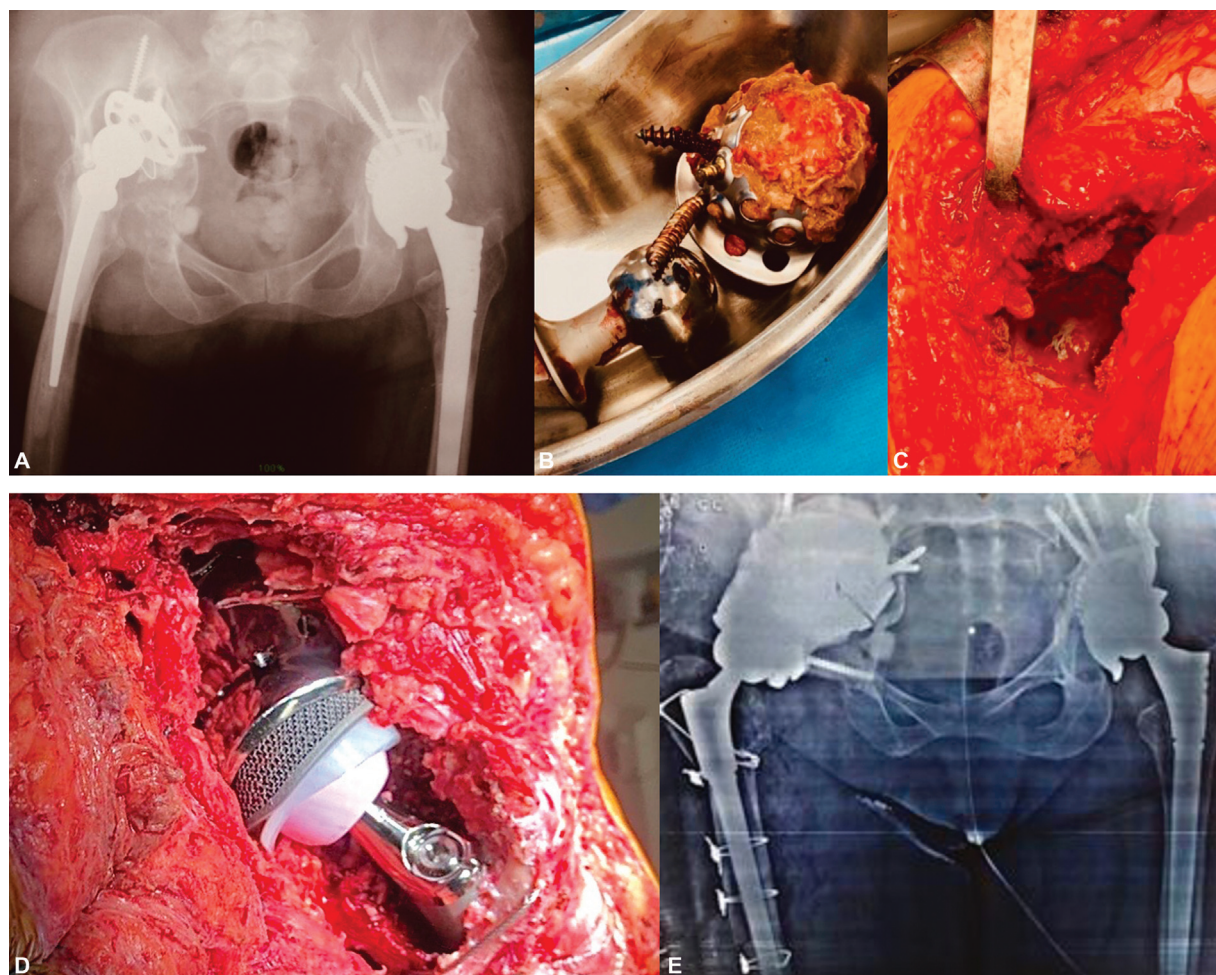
(A) Preoperative radiography; (B) removed acetabular component; (C) intraoperatively; (D) intraoperative total hip arthroplasty revision surgery; (E) postoperative radiography.
